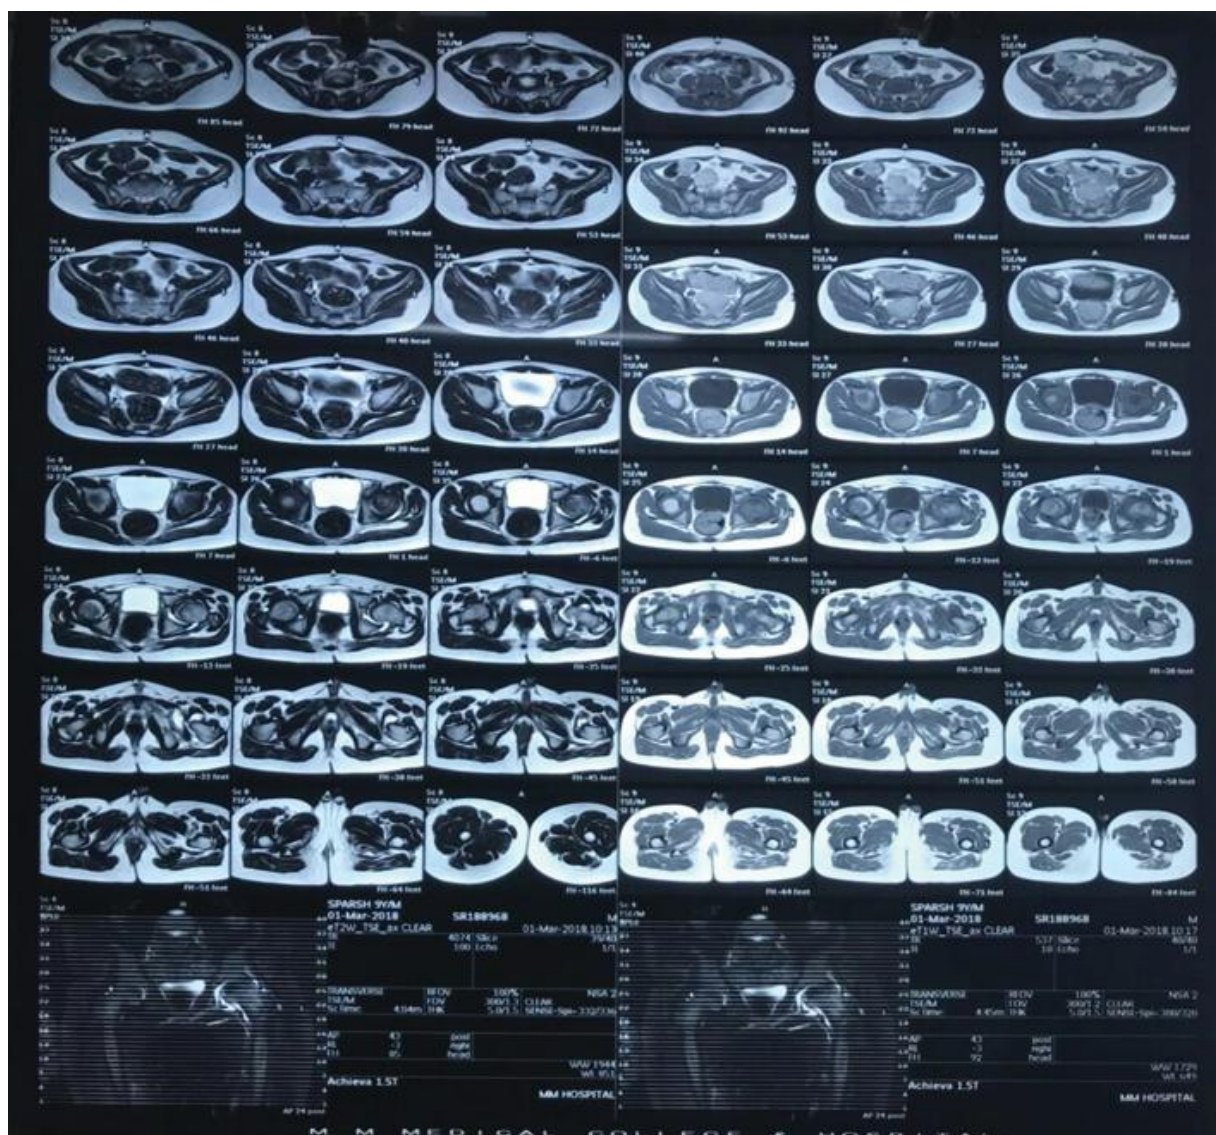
MRI of the Pelvis
